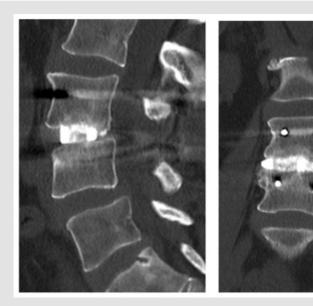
12-month CT Scans confirm complete interbody and posterolateral fusion.
